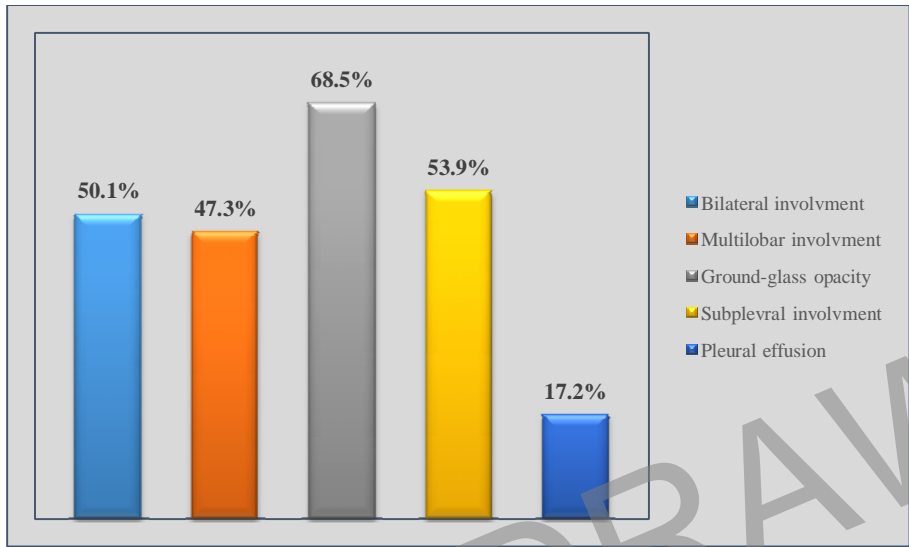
Distribution of chest CT findings of COVID-19 patients.
